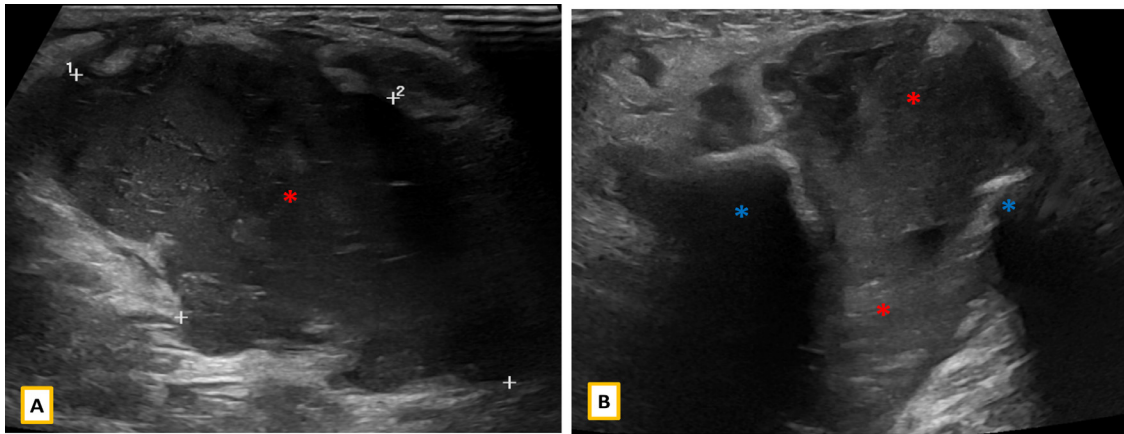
(A-B) Targeted ultrasound of the dorsal wrist joint, showing an extensor tendon collection (red asterisks), communicating with the intercarpal joints (blue asterisks).
